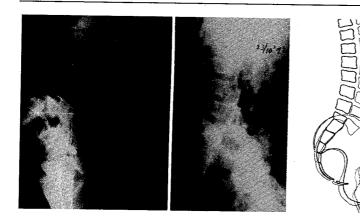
(left) Preand (center) postoperative X-rays. (right) Pre- and postoperative spinal positions.
